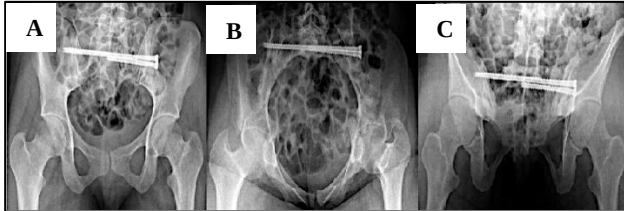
Immediate postoperative pelvic radiographs including (A) A/P; (B) inlet, and (C) outlet views demonstrating percutaneous screws fixation of the left sacral fracture.
